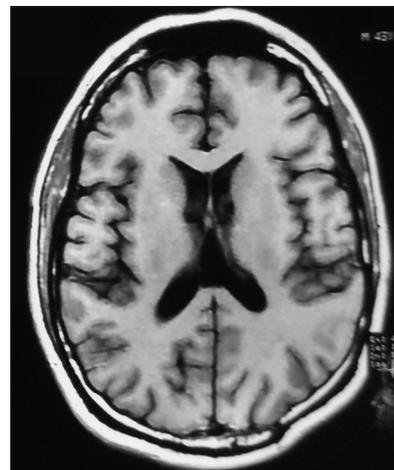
The follow up MRI after the second surgery with no evidence of cyst or hydrocephalus
